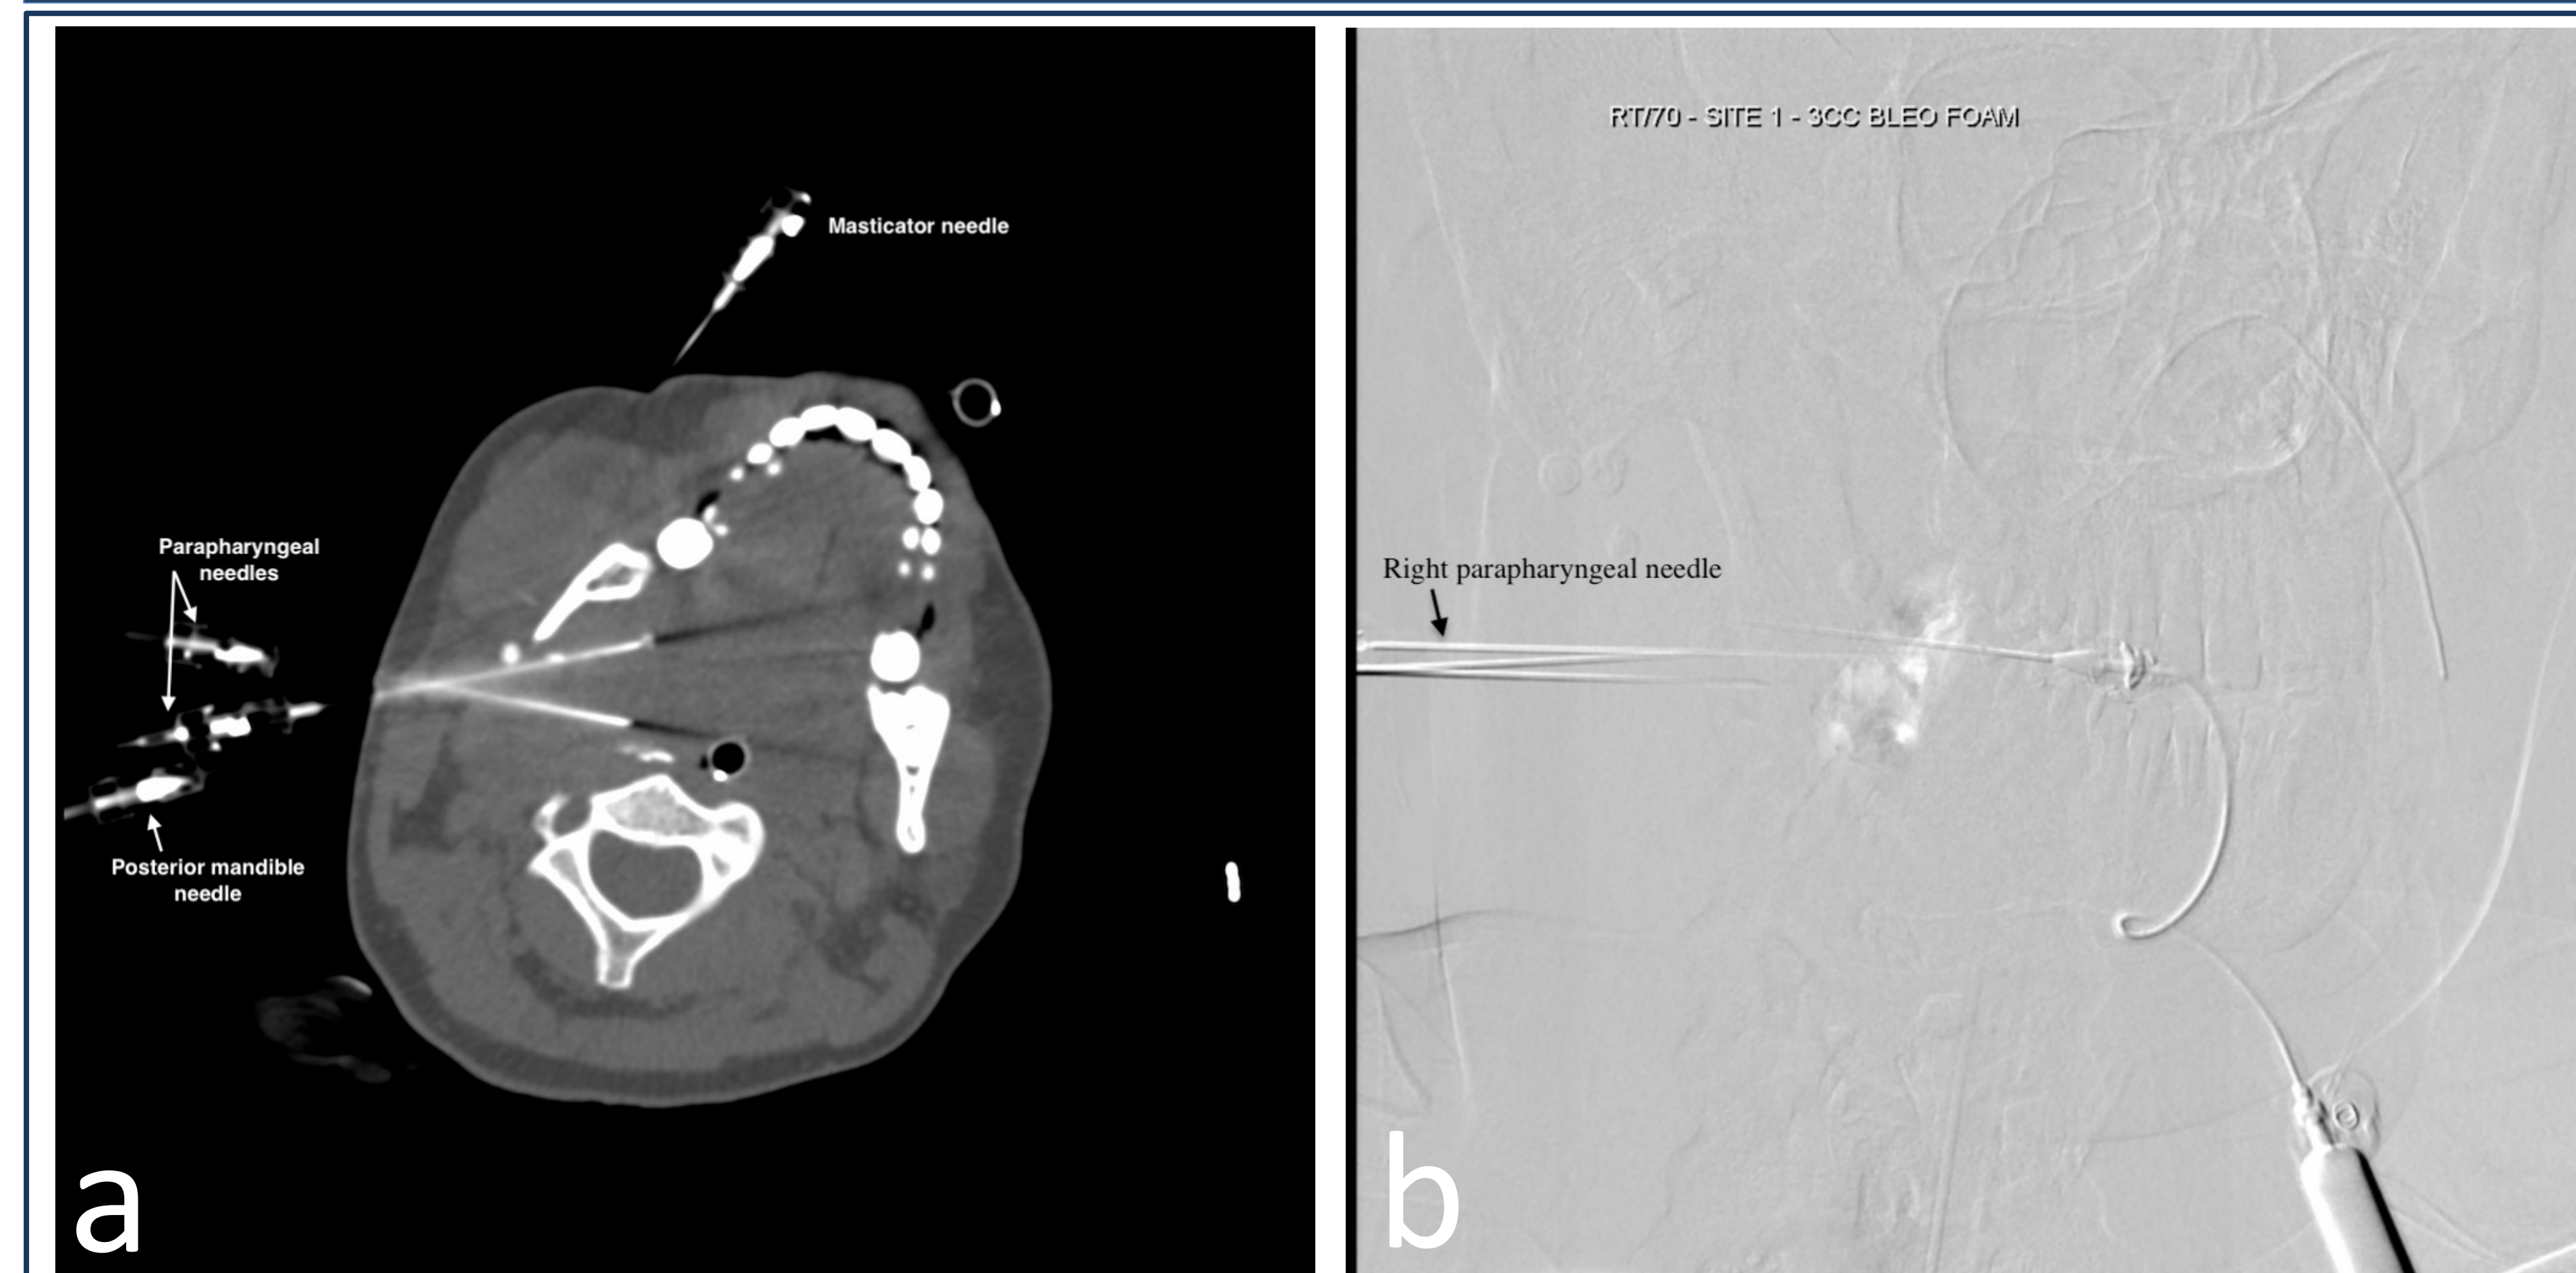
(a) Intra-procedural non-contrast CT axial image showing initial percutaneous needle placement at different components of the venous malformation. Two 7 cm 21-gauge needles are seen placed at the parapharyngeal component of the lesion. (b) Negative contrast Digital Subtraction Venography (DSV) image showing percutaneous injection of foamed bleomycin at the right parapharyngeal component of the venous malformation. 6 U of bleomycin (Pfizer, New York) in 1 mL normal saline solution plus 1 mL human 25% serum albumin mixed 2:1 air to liquid were used. A total of 31 mL foamed bleomycin was injected at 7 different sites.
